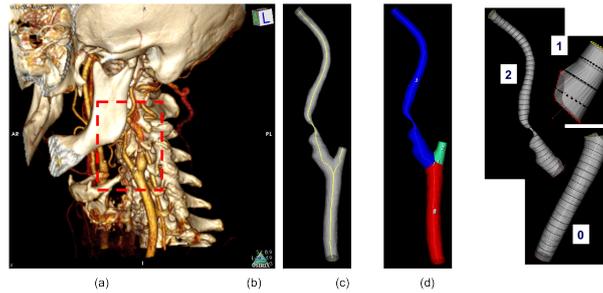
Image processing step: 3D volumetric reconstruction from CTA images (a); vascular STL surface and centerline (b); vascular surfaces after branch splitting (c); sampled sections after skeletonization process (d).
